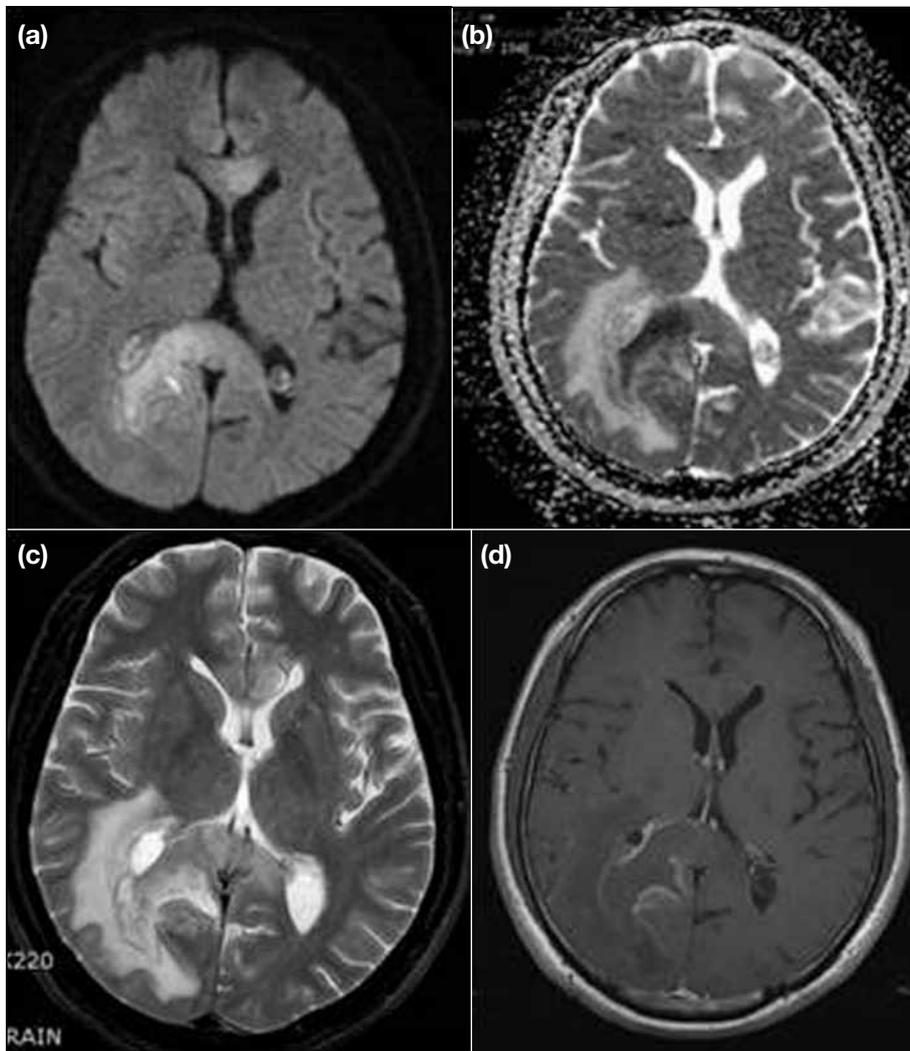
Magnetic resonance images on day 20 showing a tuberculoma. (a) A diffusion-weighted image shows increased extent of hyperintense lesion in the genu and splenium of the corpus callosum, (b) hypointensity on the apparent diffusion-coefficient map is consistent with restricted diffusion, (c) T2-weighted image shows central intermediate signal with perilesional oedema, and (d) postcontrast T1-weighted image shows peripheral enhancing rim around the lesion.
